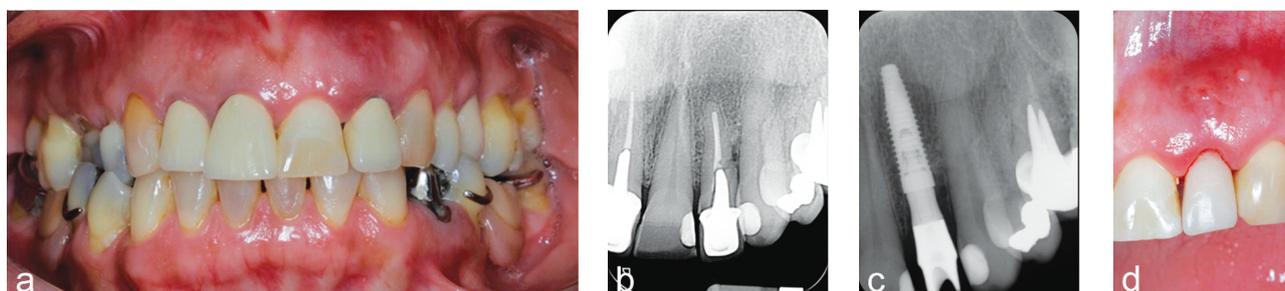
Case 2 in the preoperative phase: initial clinical aspect (a); preoperative periapical radiograph (b); implant placed immediately after tooth extraction (c); immediate crown installed (d).
